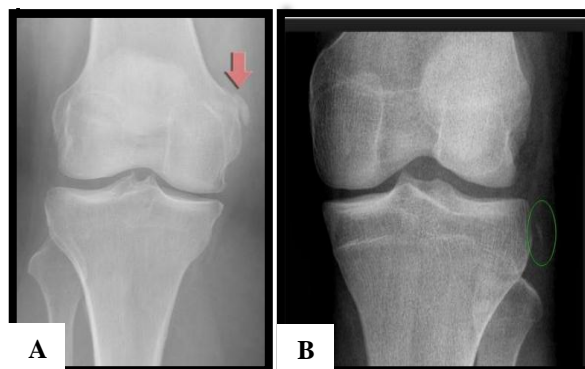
Radiograph of knee AP view showing. A: Pellegrini-Stieda lesion, B: Second fracture.
